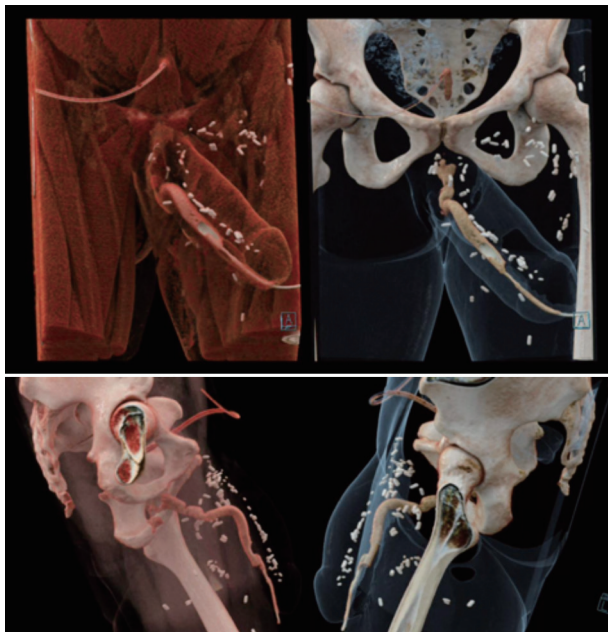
Images of 3D-reconstructed CT urethrograms using cinematic rendering. In the future, we intend to develop algorithms for determining characteristics such as total urethral volume and average cross-sectional area of the urethra to quantify anatomic factors that may be contributing to poor PP UFT or QOL scores. 3D: three-dimension; CT: computed tomography; PP UFT: postphalloplasty urinary function tool; QOL: quality of life.
